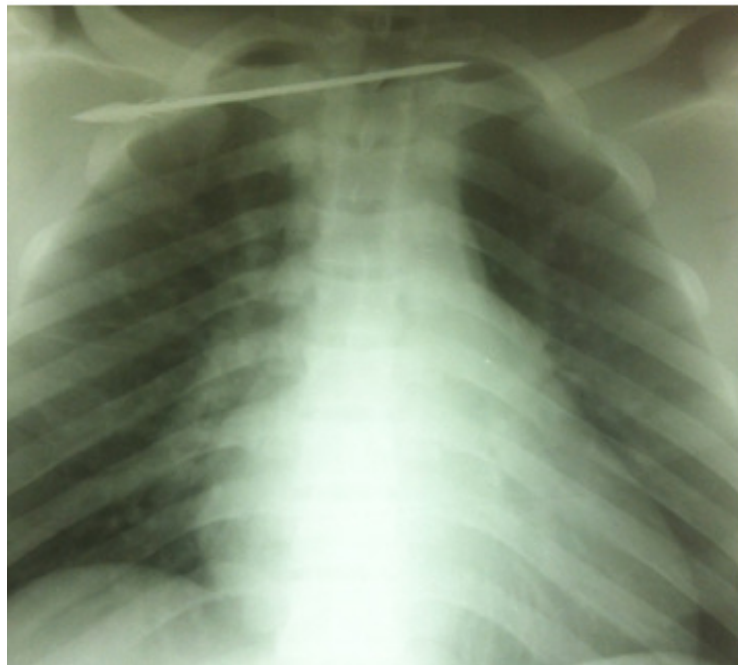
Chest radiograph showing arrow in the soft tissues of the chest.
